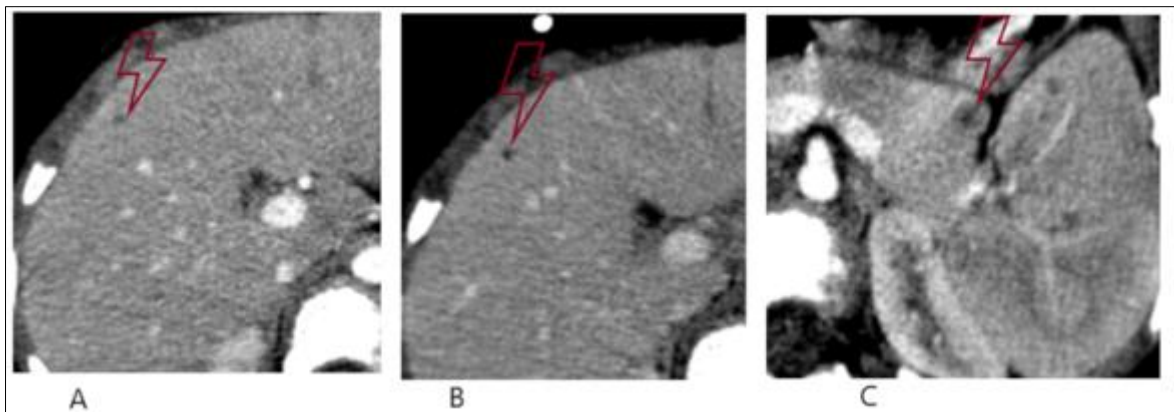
hepato-pancreatic involvement on CT scan after contrast injection:
